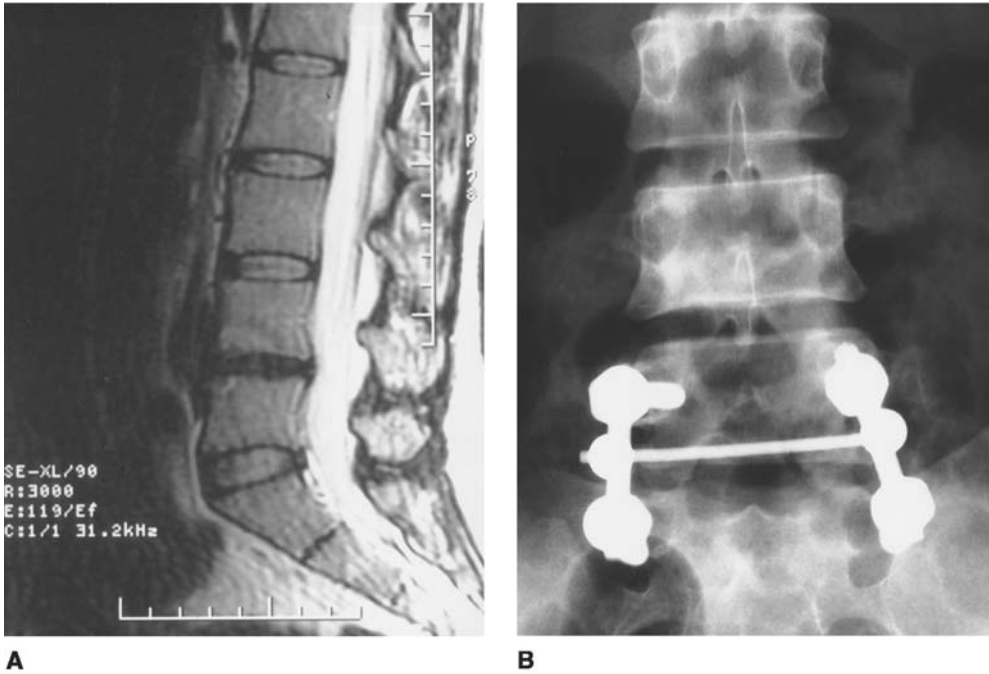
(A) Preoperative T2-weighted sagittal MRI of the lumbar spine in a 36-year-old female farmer affected by discogenic chronic low back pain unresponsive to several conservative treatment modalities over the last 2 years. Both the L4-L5 and the L5-S1 intervertebral discs show a hyperintensity zone (HIZ) in the posterior anulus. The L4-L5 disc reveals a severe degeneration when compared to the L5-S1 disc on imaging. Following provocative discography, however, only the L5-S1 disc reproduced a concordant pain and surgical indication to instrumented postero-lateral fusion at the L5-S1 level only was decided. (B) Postoperative lumbar spine roentgenogram AP view showing postero-lateral fusion with autogeneic bone grafts and transpedicular polyaxial screw/rod fixation supplemented by a transverse connector (Moss®-Miami System) at the L5-S1 level. Screws were inserted according to the inward technique described by Magerl because a synthetic model study suggested that cranially or caudally directed screws as in the up-and-in technique advocated by Levine and Edwards are prone to undergo fatigue stress; the transverse connector was added to increase rotational stability and, according to some authors, lateral bending stability as well. (C) Postoperative lumbar spine LL roentgenogram view showing sacral screws purchasing the ventral sacral cortical to increase the screw pull-out strength. The low back pain resolved after surgery, and the patient is well at a 2-year follow-up. She was advised at hospital discharge to take up a lighter job.
